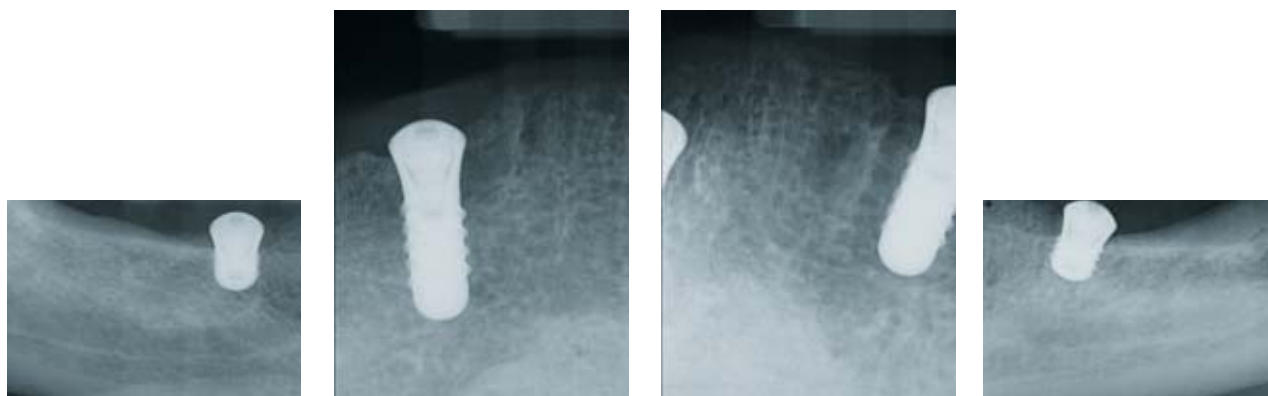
Radiographs after implant surgery, lower jaw
